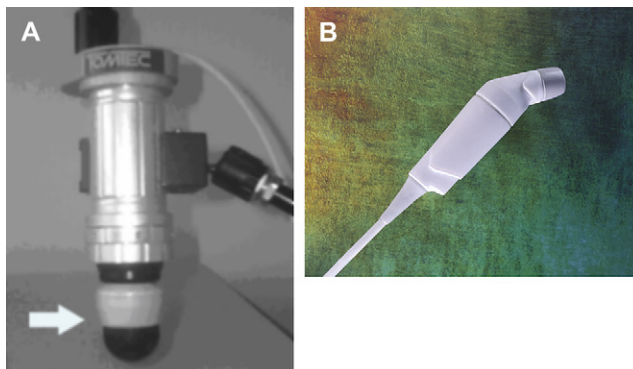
(A) An early mechanical rotator that housed an external stepper motor that controlled transthoracic echocardiography (TTE) probe rotation. (B) A transducer with rotational capacity within the head of the transducer for transthoracic imaging.
